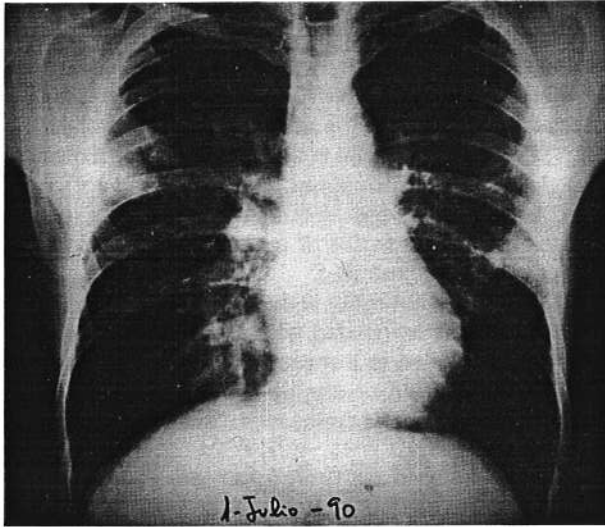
Chest X-ray showing bilateral peripheral pulmonary infiltrates in axillar regions.
